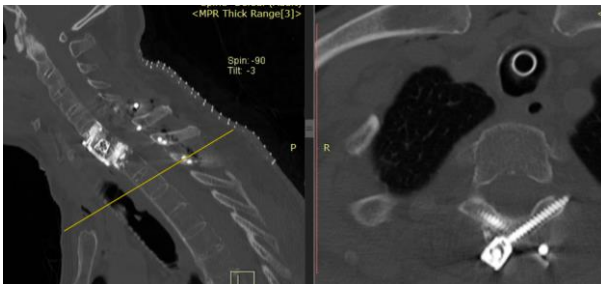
C. Cervicodorsal CT: cervical circumferential arthrodesis: C6-C7 anterior arthrodesis with cylinder and anterior plate with cemented screws. C5-Th2 posterior arthrodesis, in C5, C6 with transpedicular screws and in C7 with unilateral intralaminar screw, Th1, Th2 with crossed intralaminar screws, cross link.
